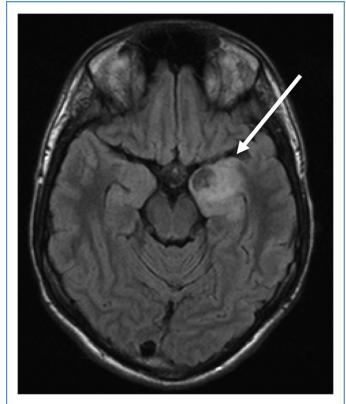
T1-weighted magnetic resonance imaging of the brain demonstrating medial left temporal lobe grade I ganglioglioma (*arrow*).
